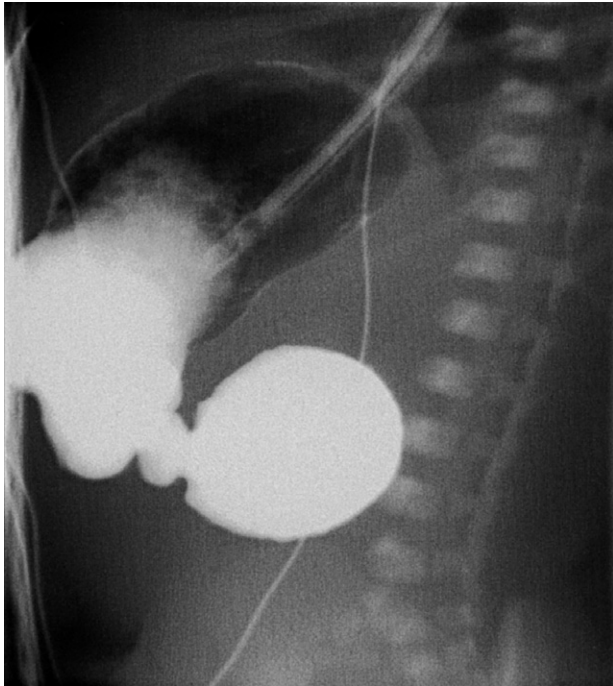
Upper gastrointestinal (UGI) radiographic contrast study of duodenal atresia.
